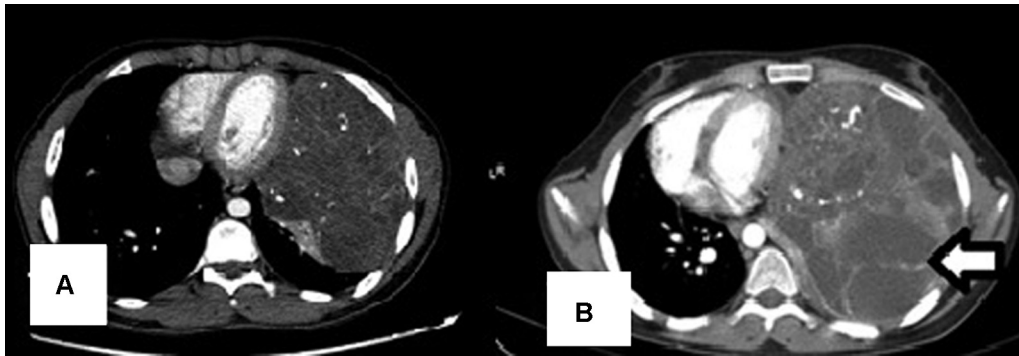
Prechemotherapy contrast-enhanced computed tomography (CECT) thorax (A) shows a left anterior mediastinal mass with solid and cystic areas and coarse calcifications. Repeat CECT after four cycles of bleomycin, etoposide, and cisplatin chemotherapy (B), demonstrating a significant increase in the size and large cystic areas within and presence of thin internal septations (arrow).
